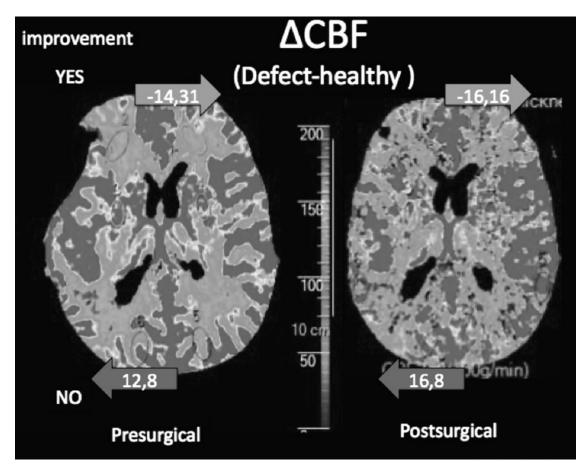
Cerebral blood flow (CBF) asymmetry. When the CBF value obtained in the perfusion CT of the healthy side is subtracted from the defective side, a great asymmetry in favor of the healthy side (14.31 mL/100 g/min more) in the healthy than in the defective side) is observed in patients who showed neurological improvement, whereas the asymmetry favors the defective side (12.8 mL/100 g/min) min more in the defective than in the healthy side) in patients who showed no improvement. These findings are more pronounced after the surgery.
